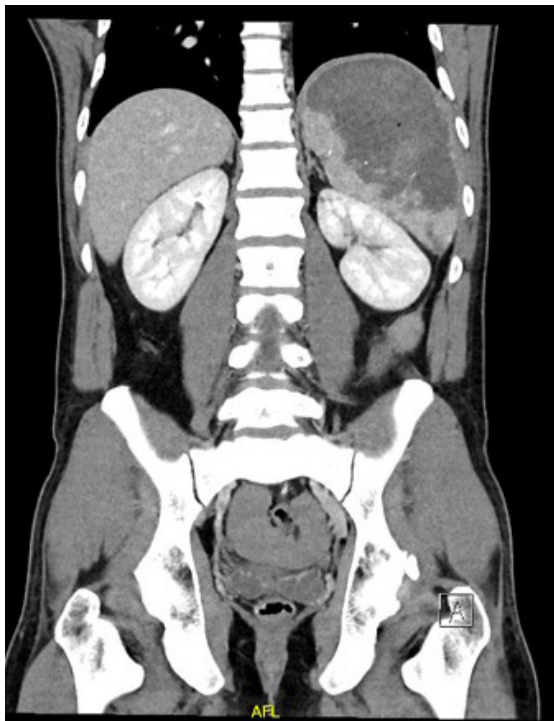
CT scan abdomen, coronal view showing splenic parenchyma with heterogeneous liquefaction changes and peripheral ring of enhancement with air locules within the parenchyma.
